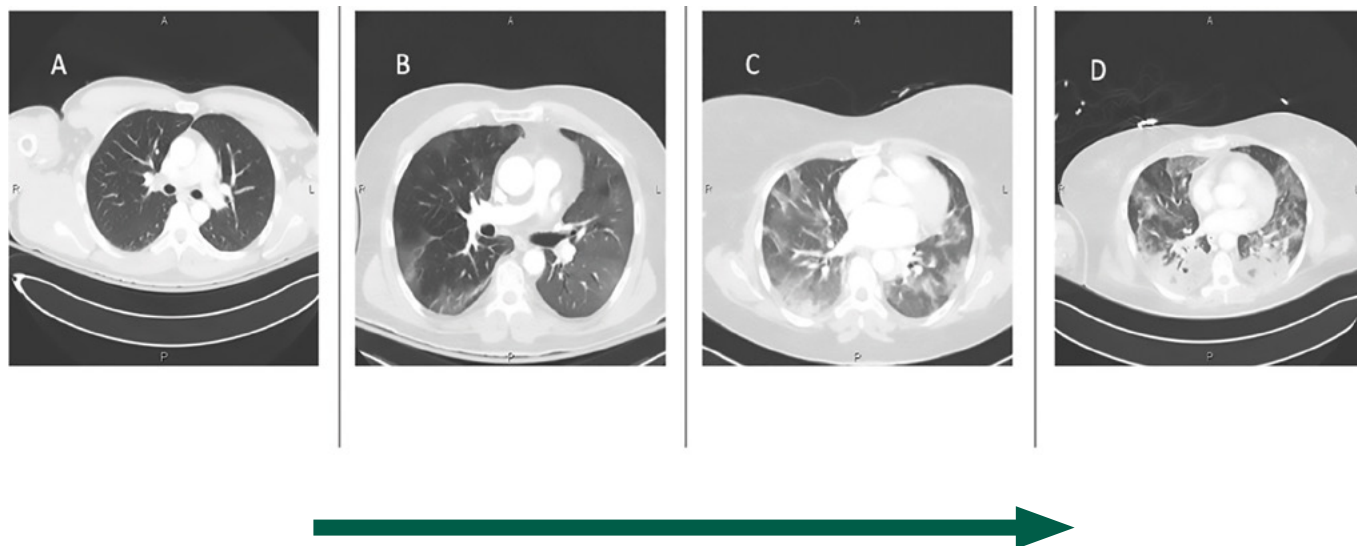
Progression of COVID-19 infection on CT during 72 hrs in a patient with hypoxaemic respiratory failure. Images reproduced with permission from the archives of the Department of Diagnostic Radiology, University Hospital Bulovka, Prague, Czech Republic
